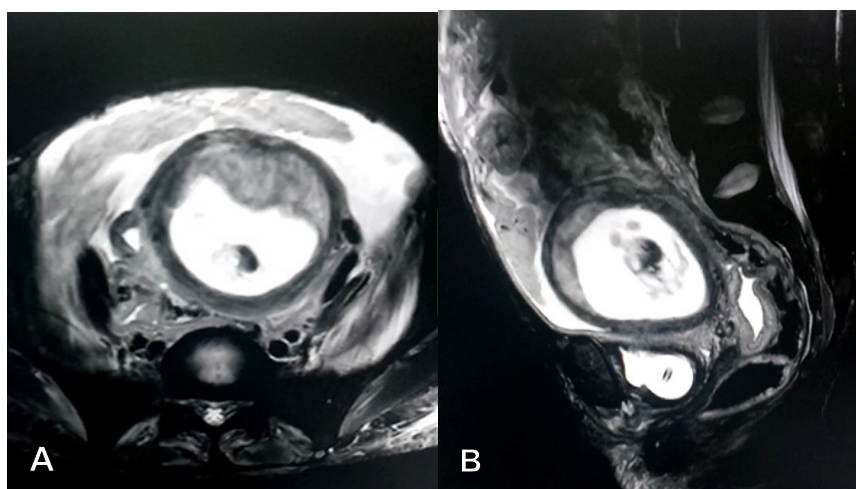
Pelvic MRI showing intrauterine pregnancy; A: Coronal view; B: Sagittal view.
